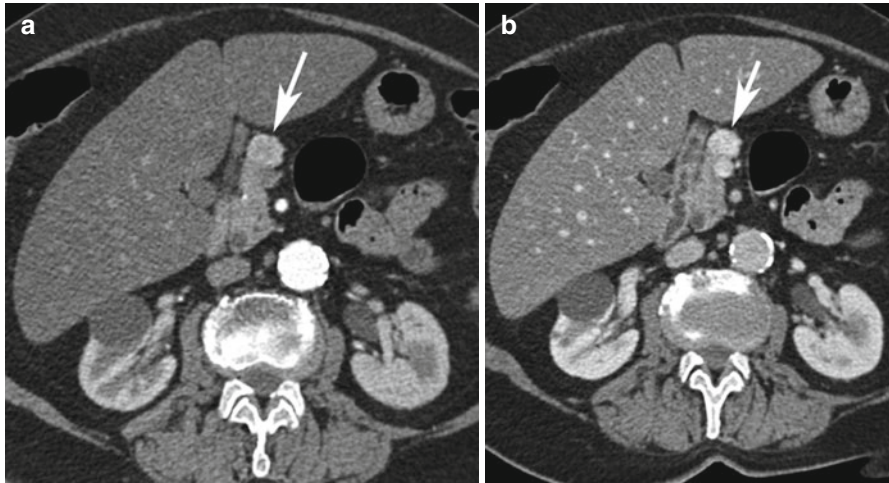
Insulinoma in neck of the pancreas. An 81-year-old female presented with hyperinsulinaemia. (a) Arterial-phase CT shows an 18 mm arterially enhancing lesion in the neck of the pancreas (arrow); (b) portal-venous-phase CT shows that the lesion remained avidly enhancing (arrow)
